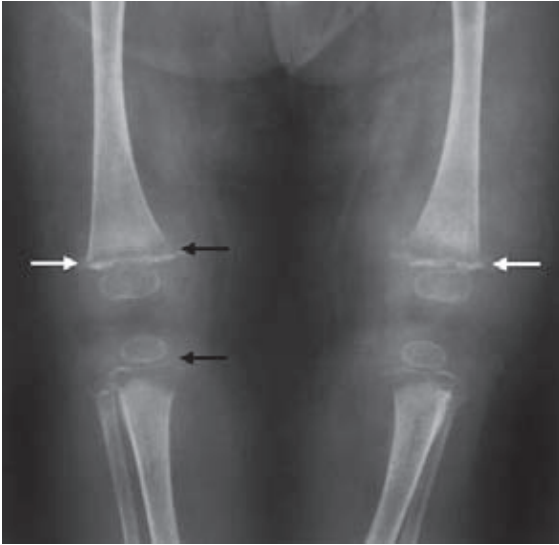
Scurvy. AP radiograph of the knees. Transverse bands of metaphyseal lucency lie adjacent to dense zones of provisional calcification (white arrows). There are metaphyseal corner fractures through the weakened metaphyses (white arrows)
